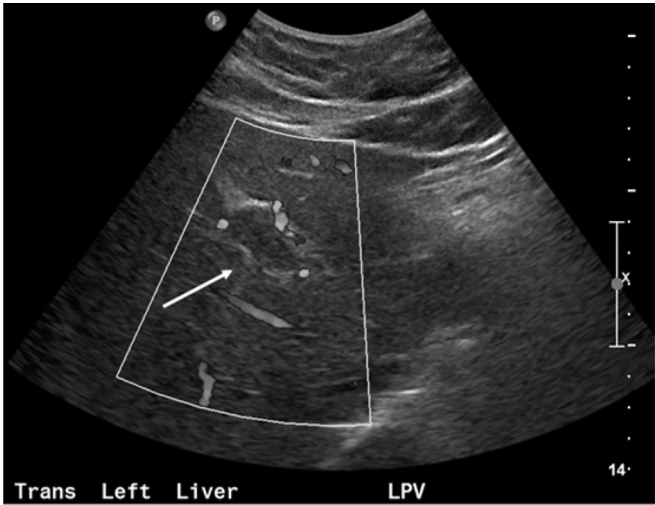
Ultrasound demonstrating left PVT (arrow).
